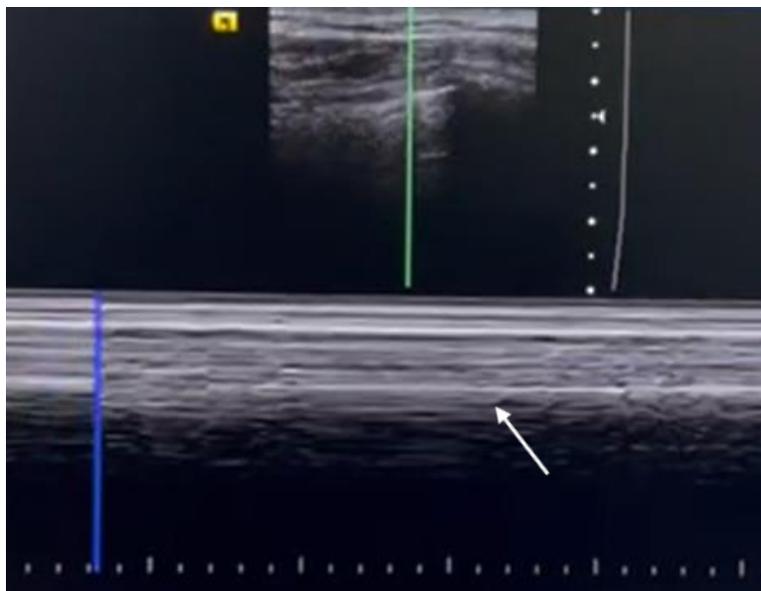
M-mode lung ultrasound (note the arrowed stratosphere sign)
